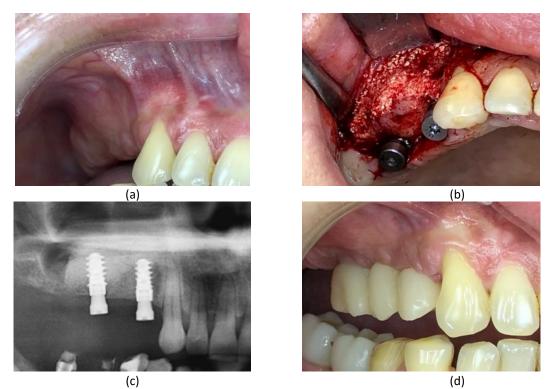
Implants placement: (a) Soft tissue condition eight months after grafting; (b) Implants placed into the very hard ``granules/new bone formation`` at eight months after grafting; (c) X-ray control immediately after surgery; (d) Soft tissue condition three months after provisional restoration.
